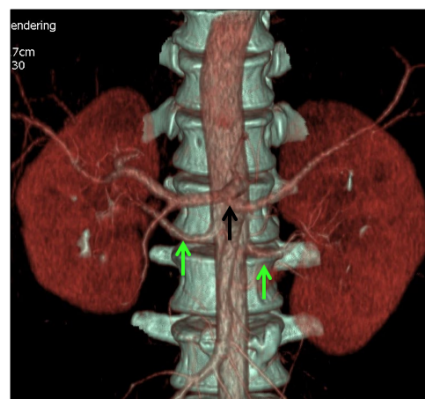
3D Reconstructed, Volume rendered CECT image showing normal CT (Black arrow) and normal bilateral single renal hilar arteries (Green arrows).
